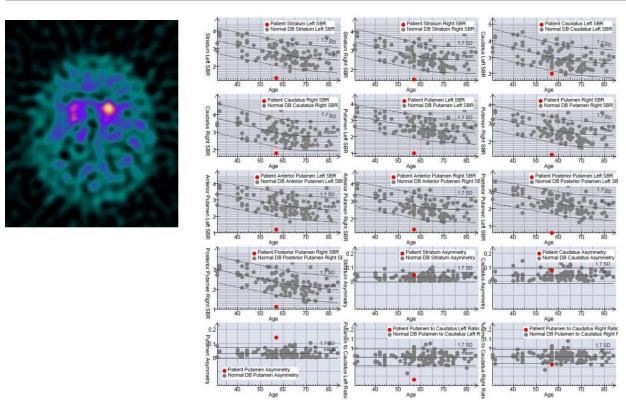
Visual and quantitative analyses of DaTscan SPECT in a patient with Parkinson disease associated with speech abnormalities, akinetic phenotype and autonomic dysfunction, axial section shows reduced [123I]FP-CIT uptake in the right caudate and in both the putamen, quantitative assessment of tracer uptake (DaTQUANT software, GE Healthcare®) confirms the visual findings, but also indicates reduced uptake in the left caudate compared to normal controls
